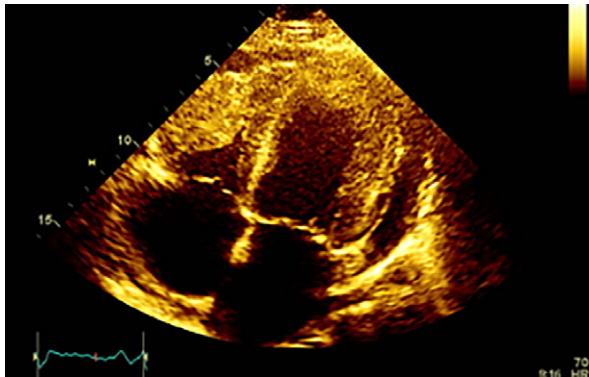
Transthoracic echocardiogram (apical 4-chamber view) reveals a large mass in the right ventricular free wall and a moderate-sized pericardial effusion.
